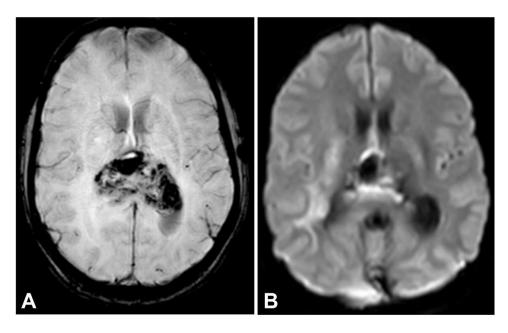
SWI axial section showing areas of blooming within the lesion, and DWI axial section showing areas of restriction.
